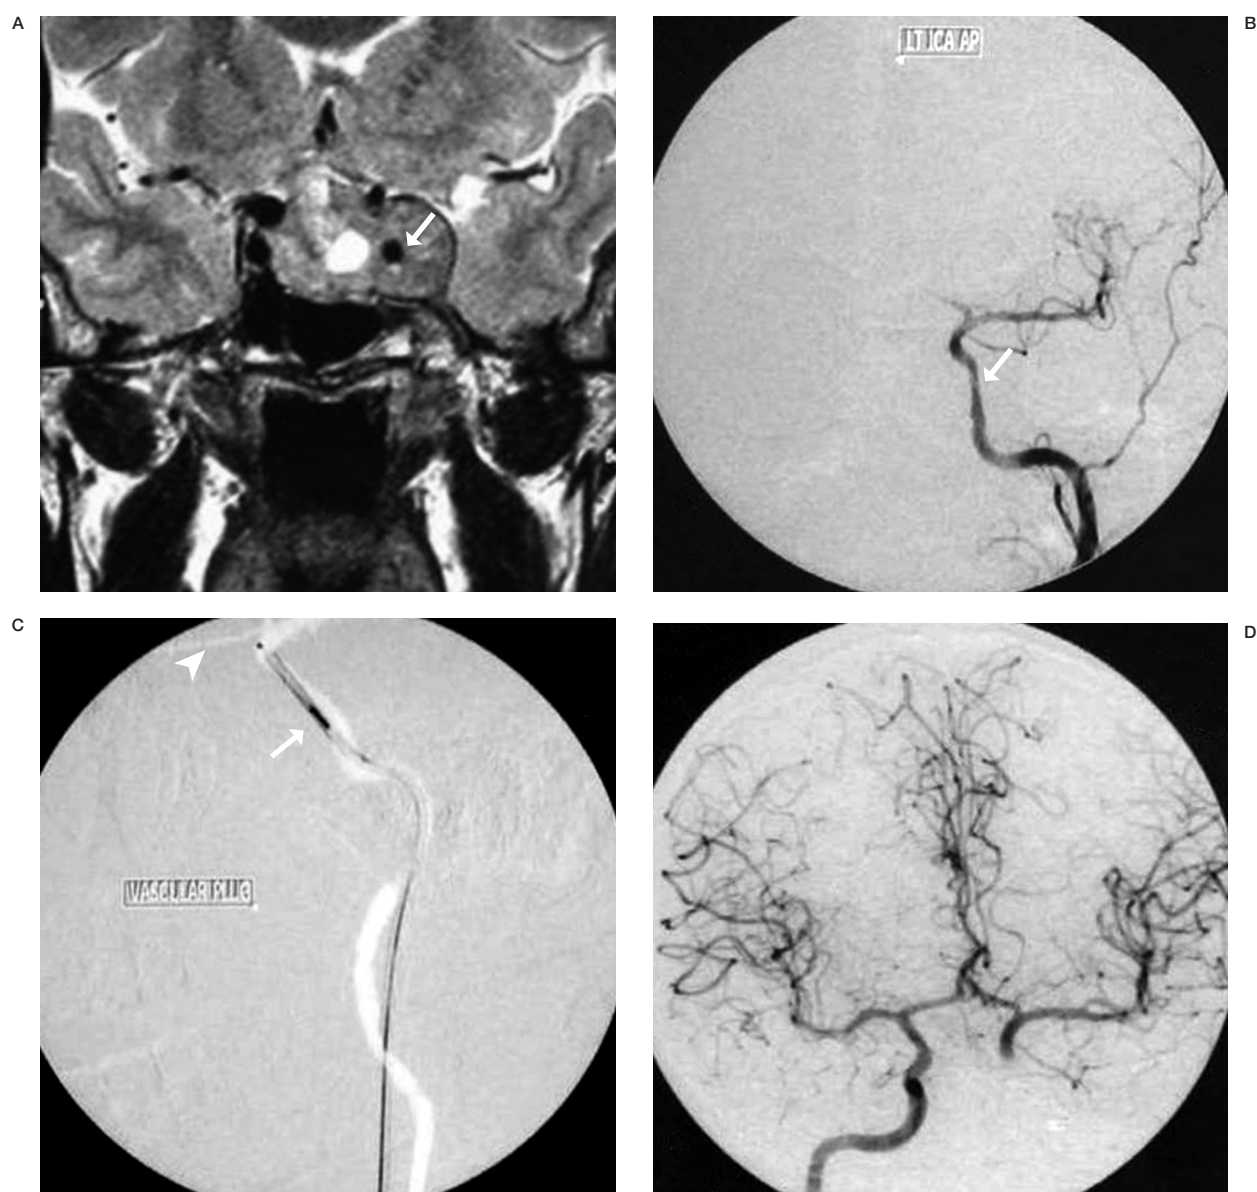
A) Coronal MRI of brain showed left ICA completely encased by the pituitary adenoma (arrow). B) Towne's view of left ICA angiogram showed irregular and narrowed distal cavernous segment (arrow) of left ICA (angiogram with nasal packing in place with continuous oozing of blood from nasal packs). C) Vascular plug (arrow) with distal and proximal markers deployed at the site of rupture, ophthalmic artery (arrowhead). D) Right ICA angiogram post occlusion of left ICA showed adequate cross circulation.
